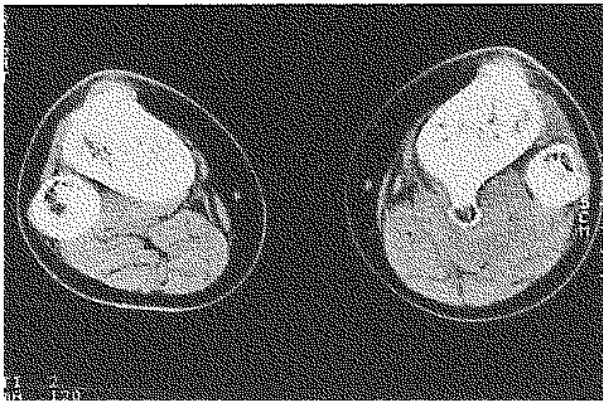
CT Scan: small amount of fluid in the deep proximal calf.
